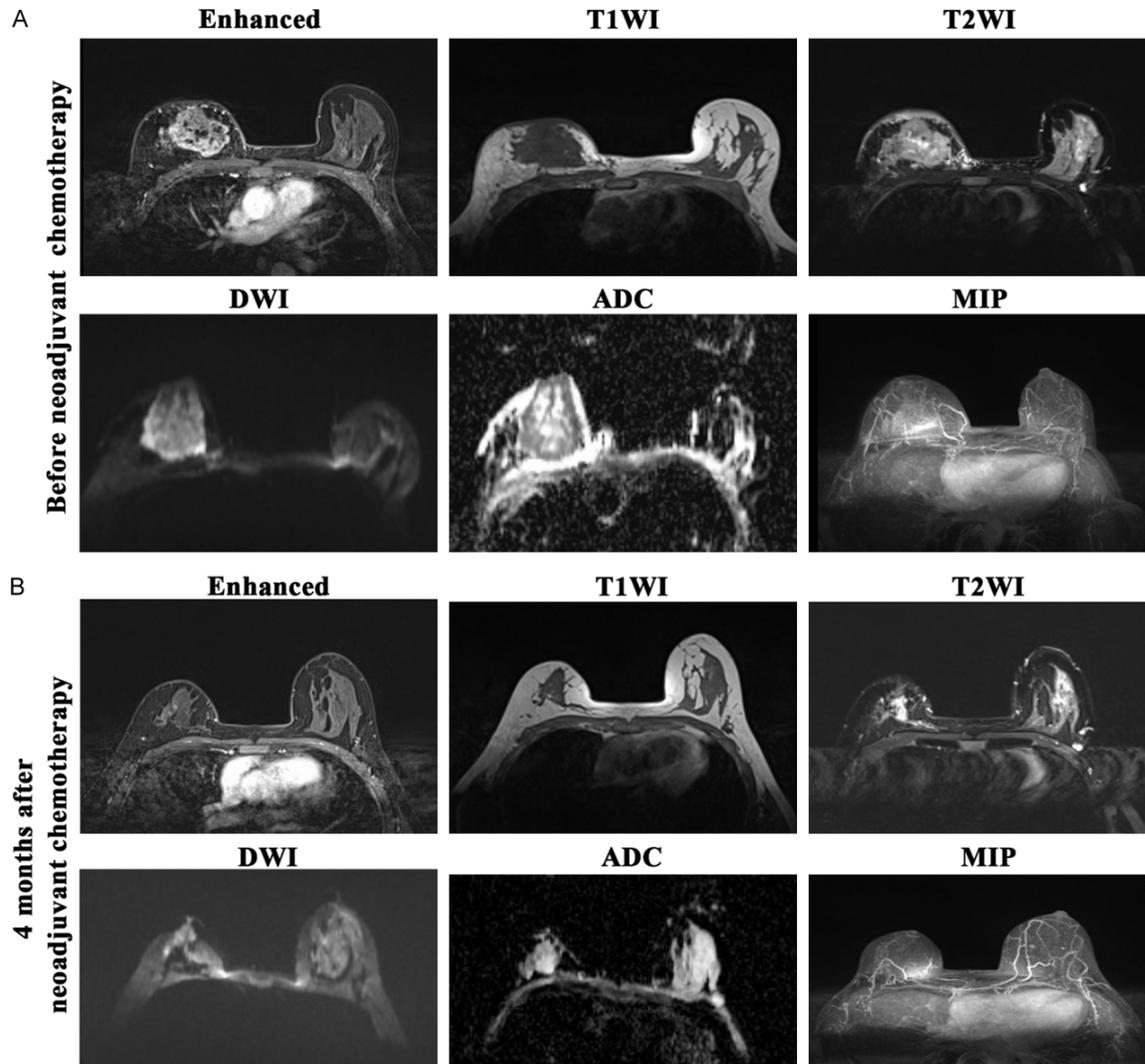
MRI images of a 48-year-old female case before and after neoadjuvant chemotherapy. A: Before neoadjuvant chemotherapy; B: 4 months after neoadjuvant chemotherapy. DWI, Diffusion weighted imaging; ADC, Apparent dispersion coefficient; MIP, Maximal intensity projection.
